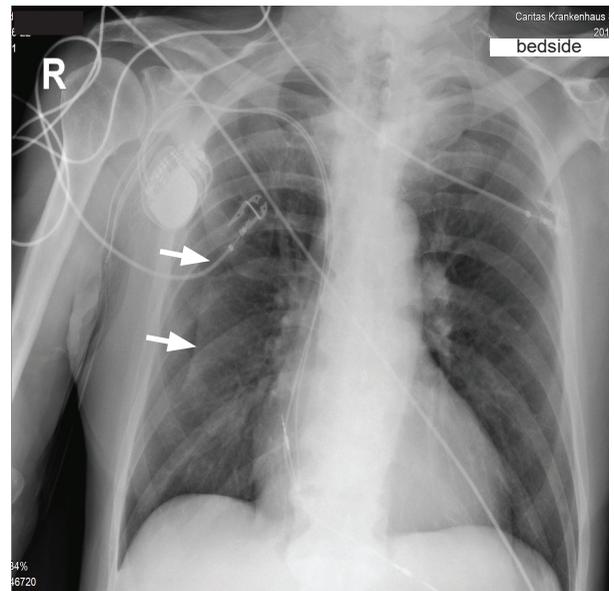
pitfall skin fold (here routine chest x-ray after the implantation of a permanent pacemaker): On the right, there is no pneumothorax, just a skin fold (see arrows). The line runs over the lung border, furthermore the vessels can be seen up to the periphery.
